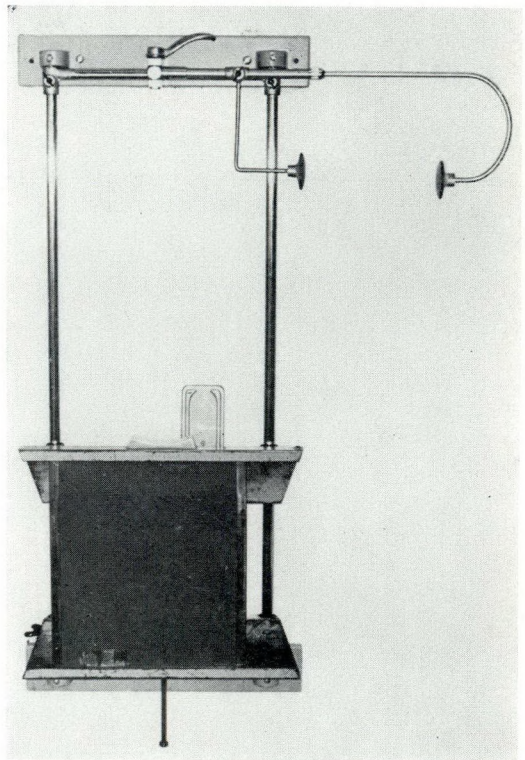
The head attachment for the roentgenogram plate stand; the plate holder slides into position.
